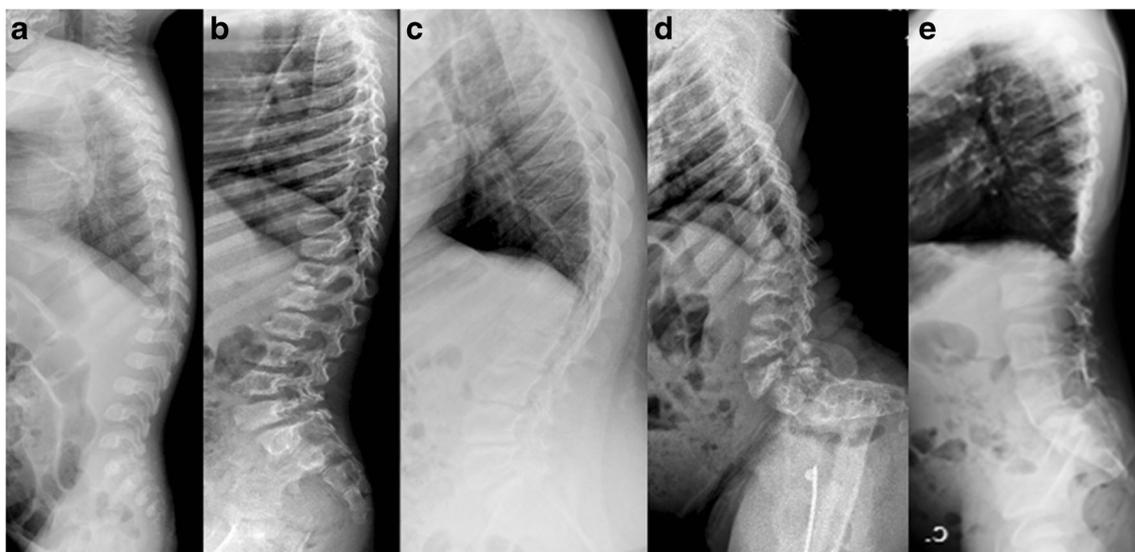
Profile view of the spine radiographs of the five ML patients. Patient a is affected by ML II and patients b to e are affected by ML III; a 11-month-old male ML II patient (P1) showing dorsolumbar kyphosis, short anteroposterior diameter of the vertebral bodies with mild anterosuperior hypoplasia of the upper lumbar bodies more evident in T12; b 9-year-old male ML III patient (P2) showing short anteroposterior diameter of the vertebral bodies with mild anterosuperior hypoplasia of the upper lumbar bodies more evident in T11–T12, with endplate irregularities; c 17-year-old female ML III
